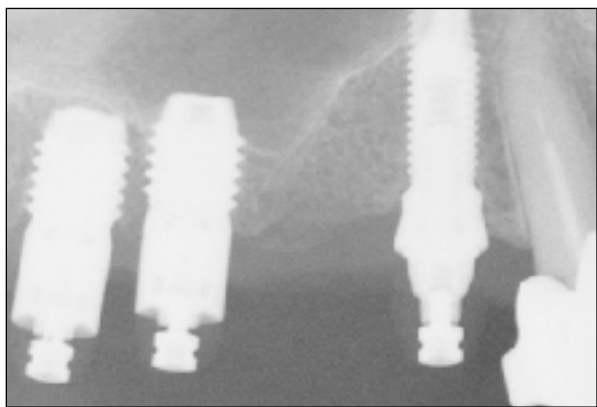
Radiograph showing clinical situation of 2 implants 5 mm wide and 6 mm long. Shortly after stage 2 surgery, the bone level remained at the collar.
